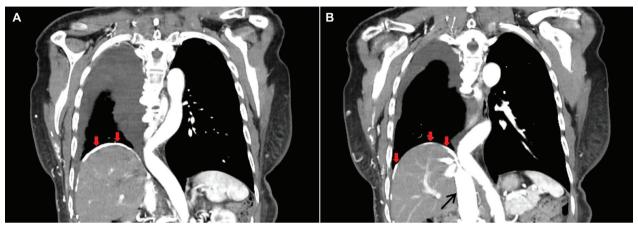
Coronal view of the chest CT image (A and B) showed the right phrenic venous route (red arrows) drained into the inferior vena cava (black arrow).
